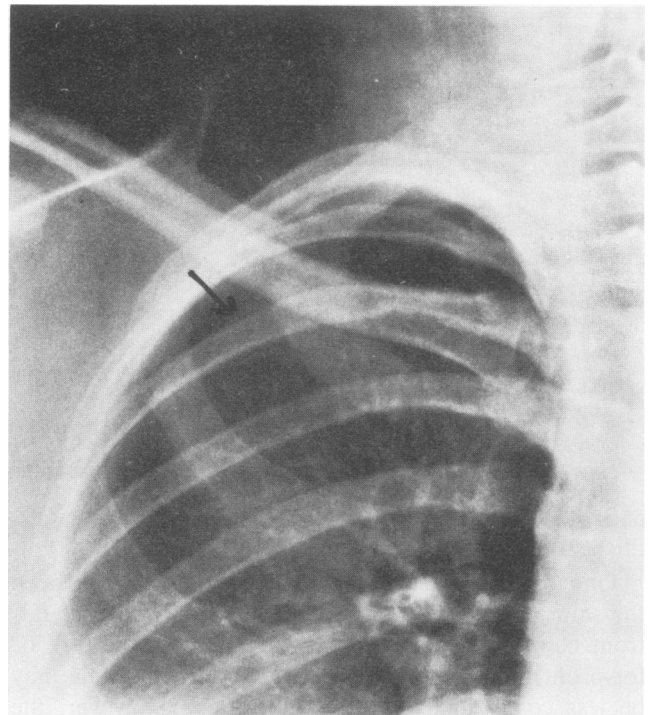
An x-ray study showing small pneumothorax (arrow) on right side of patient's chest.
